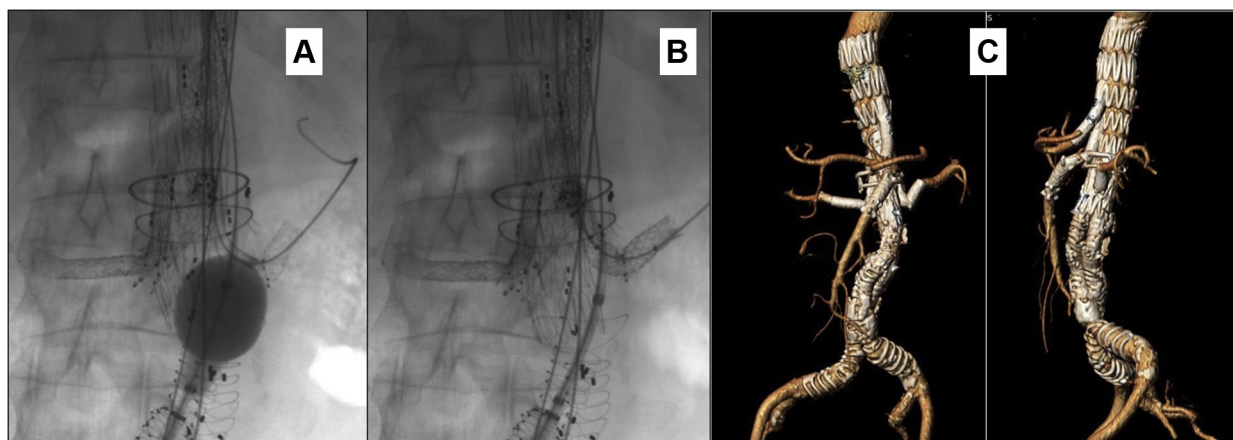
A, Imaging study after deployment of the right renal stent showing the use of the Coda Balloon (Cook Medical) to exchange the guidewire in the left renal artery. B, BeGraft Plus stent (Bentley Innomed GmbH) deployment in the left renal branch with no improvement of the previous angulation. C, Three-dimensional reconstruction of the 2-year follow-up computed tomography scan showing patency of all branches and extreme angulation of the left renal BeGraft Plus stent (Bentley Innomed GmbH).
